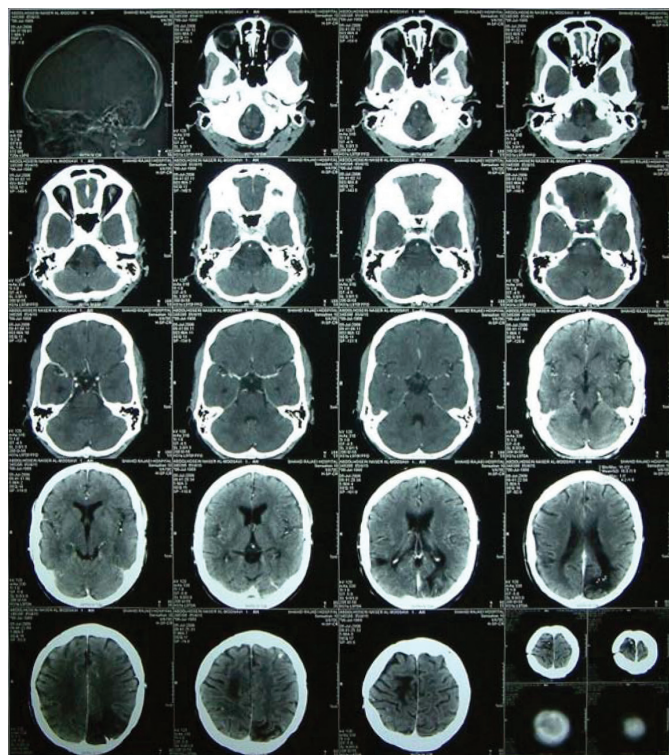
Brain CT –Scan of the patient
